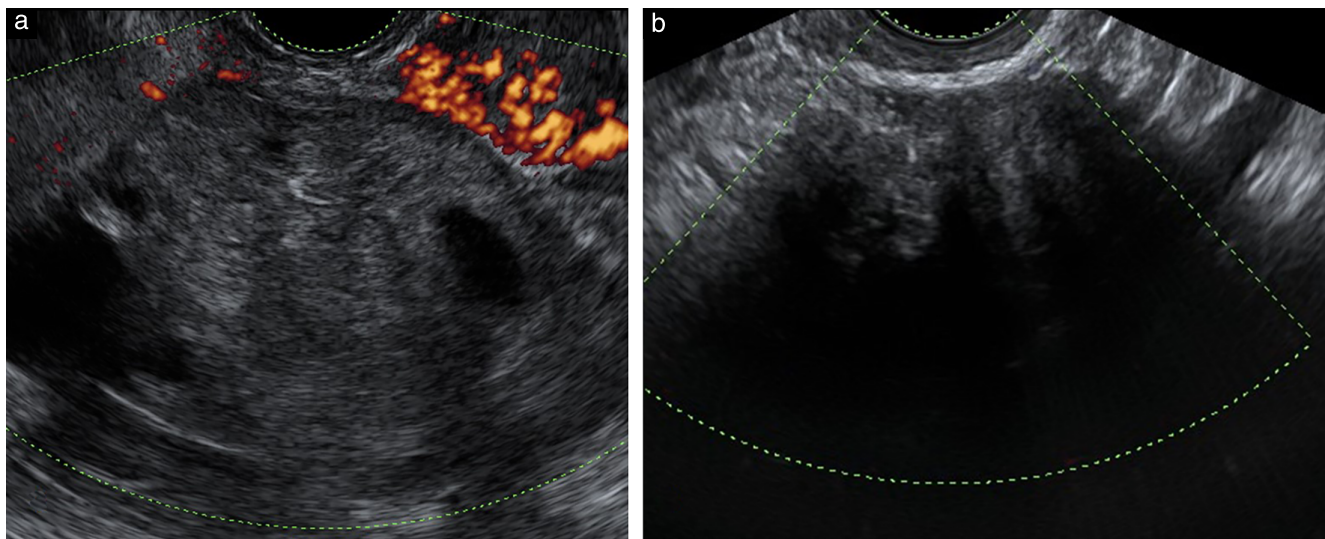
Power (a) and color (b) Doppler ultrasound images of solid serous cystadenofibromas in 48-year-old women. Shadowing is seen.
